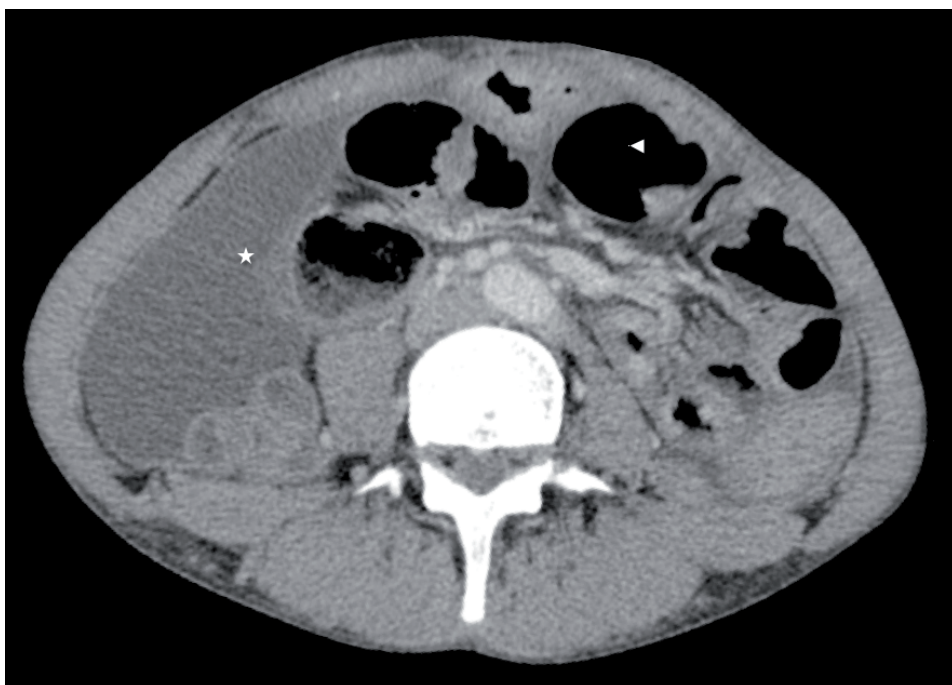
Computed tomography imaging of the abdomen in case 2 showed dilated small-bowel loops (arrowhead) and ascites (star), but no classical signs of encapsulating peritoneal sclerosis
